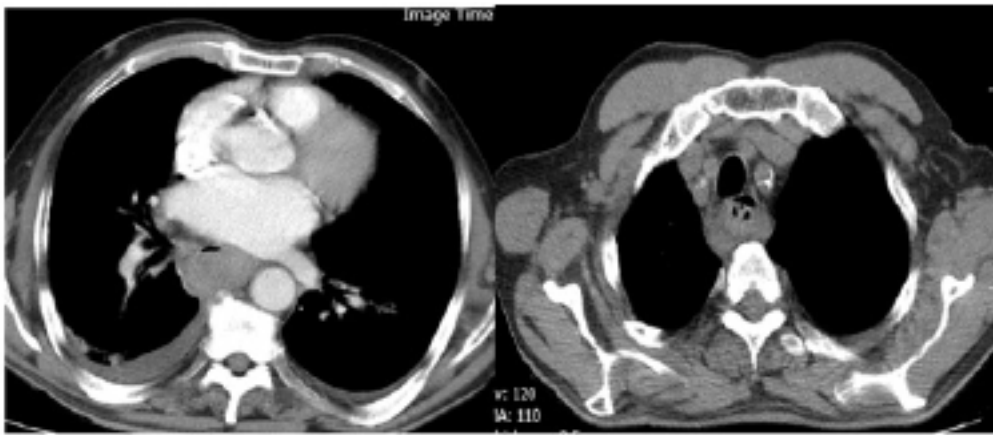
CT-scan of the chest show (IHE) upper portion of esophageal and leakage of blood to pleural space.
